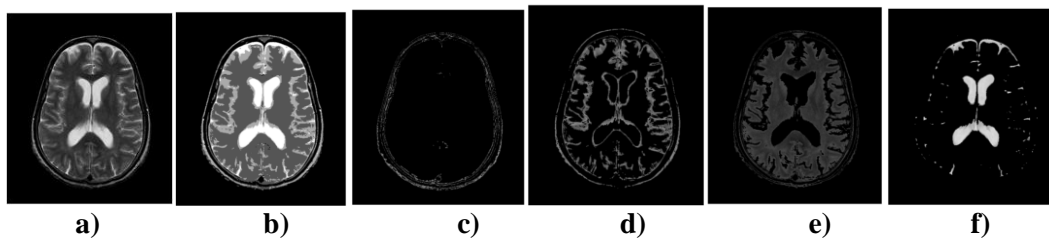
16 Fuzzy k-means algorithm applied on MRI slice. a) Original MRI slice, b) Clustered MRI slice, c) Objects in cluster 1, d) Objects in cluster 2, e) Objects in cluster 3, f) Objects in cluster 4.
